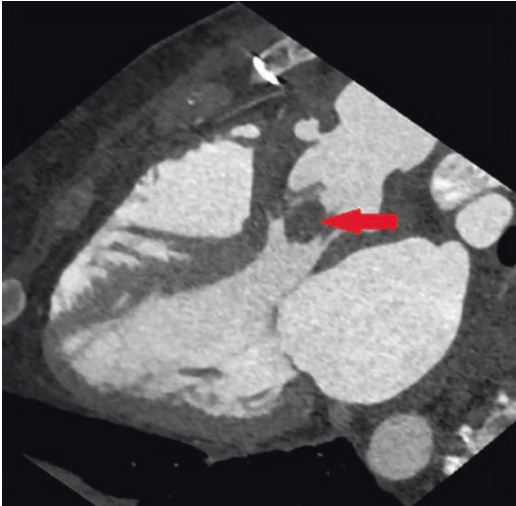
Cardiac CT showing vegetation of infective endocarditis of the native aortic valve (red arrow)
